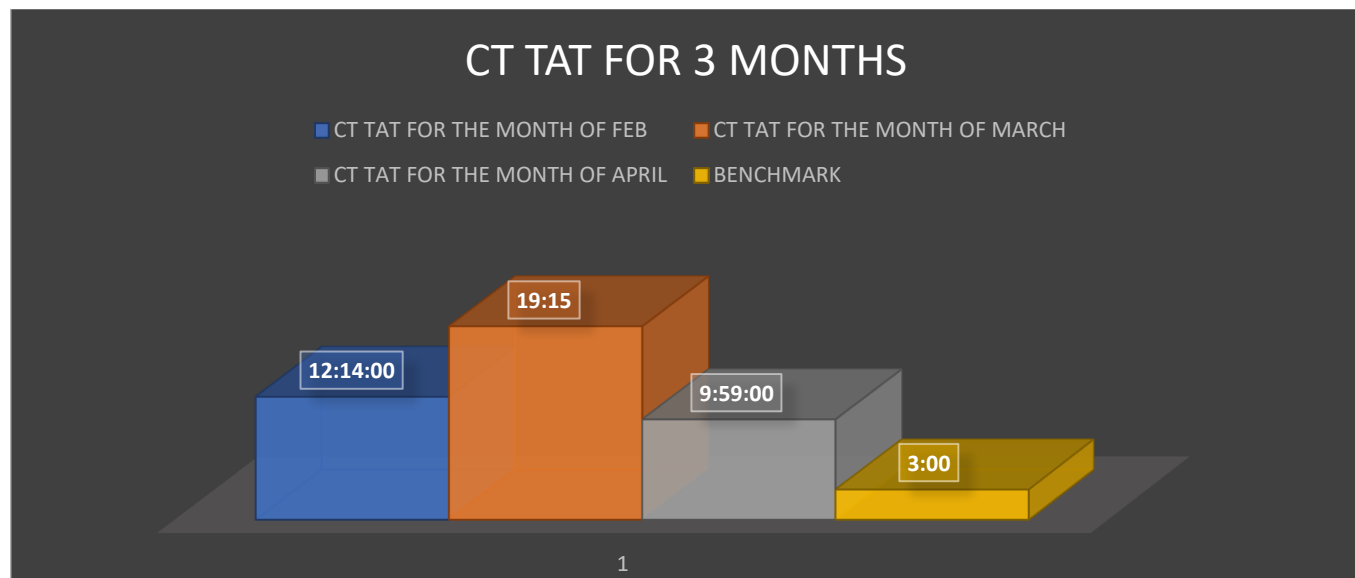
Represents the CT TAT for 3 consecutive months in comparison with the benchmark (From Feb till April)
